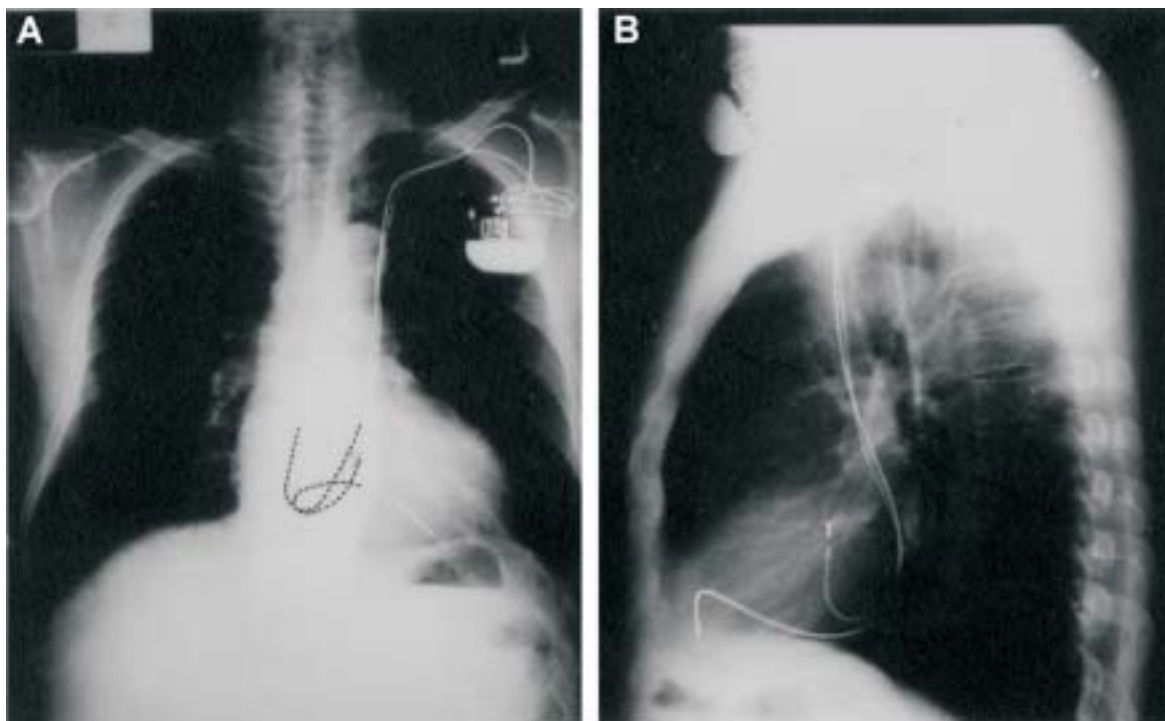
The post-procedure chest radiography showed the ventricular lead tip located in the antero-apical part of the right ventricle and the atrial lead located at the interatrial septum. Both pacing catheters followed an abnormal course along the left border of the thoracic spine and entered the right heart chambers after passing through the coronary sinus.
